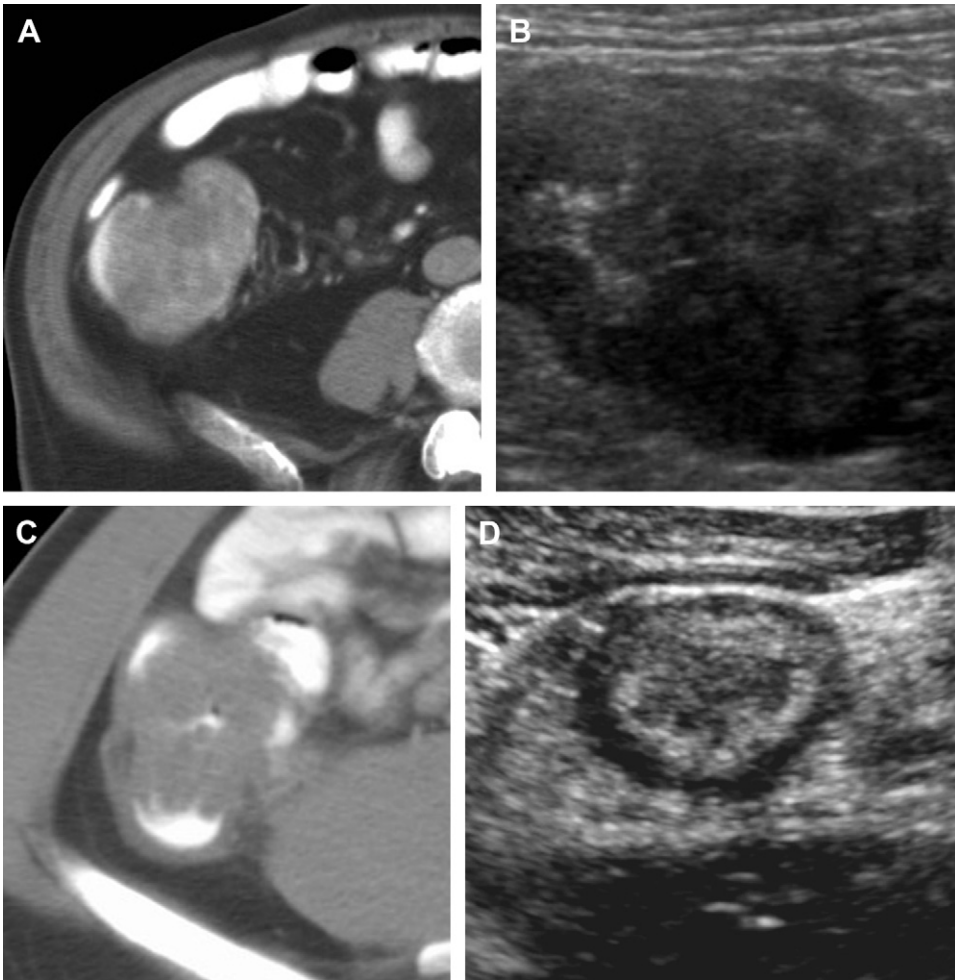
(A) Focal nonspecific thickening on CT involving the right colon in a patient with right lower quadrant pain. (B) Same patient on US demonstrating typical features of malignancy, including loss of bowel wall layers and eccentric and bulky short segment thickening. Right colonic adenocarcinoma at scope. (C) Separate patient with right lower quadrant pain and nonspecific focal thickening of the right colon on CT. (D) Same patient with preservation of bowel wall layers confirming inflammation rather than malignancy.
